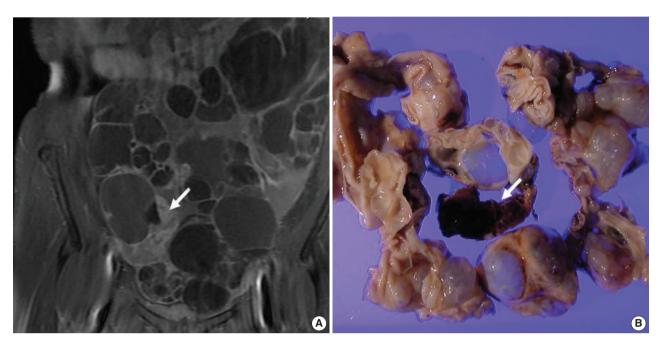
(A) The magnetic resonance image of the abdomen shows the presence of a 26×19×10 cm sized, multilocular, thick walled cystic mass with some solid areas and contrast enhancement (arrow). (B) Grossly, the tumor is a multilocular, cystic mass that is filled with mucinous fluid and there are multifocal solid and hematoma-like areas (arrow).
